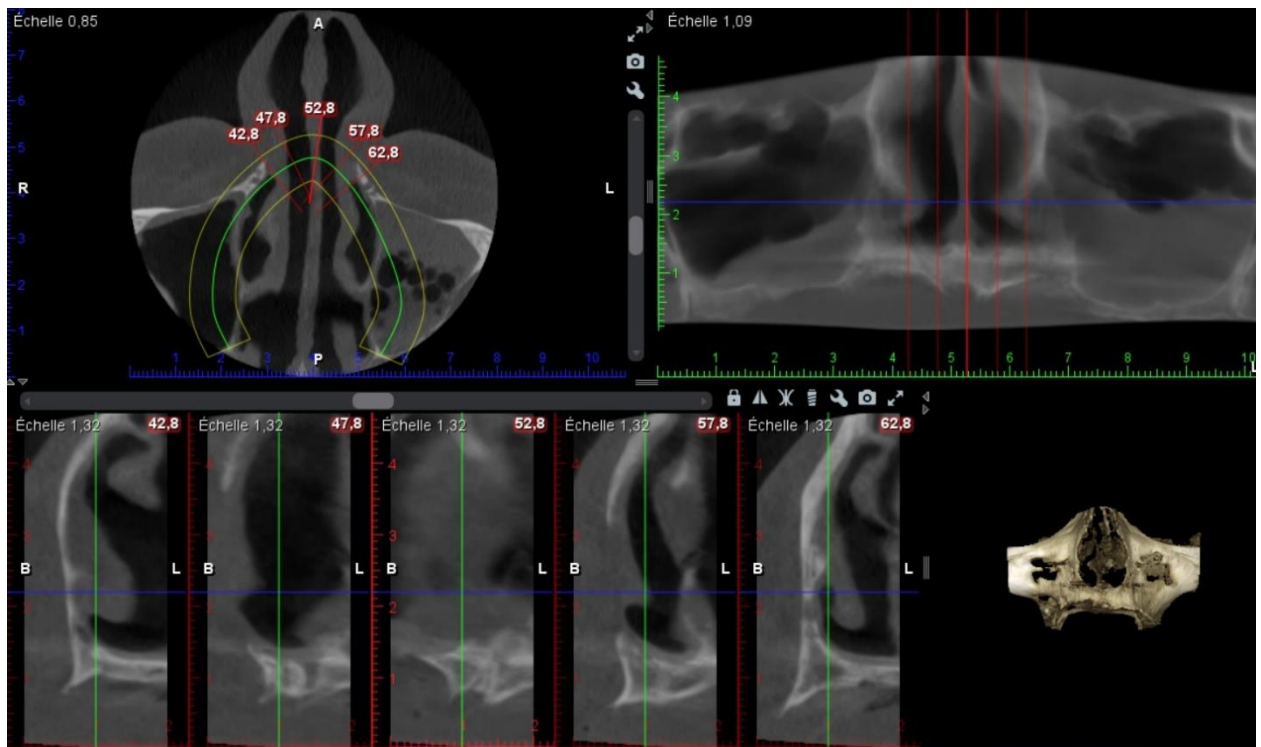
CBCT of the patient with severe atrophy of the upper jaw.
